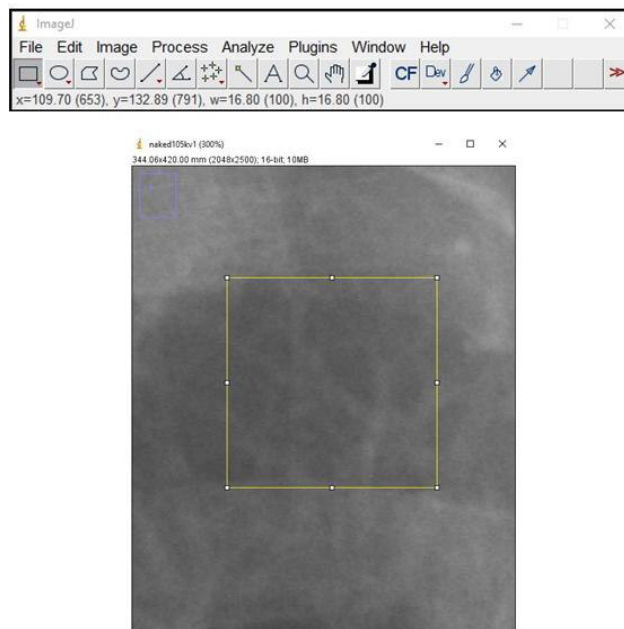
Radiograph was expanded 300% and Rectangular Selection Tool was selected to measure the gray value of each point using ImageJ.
